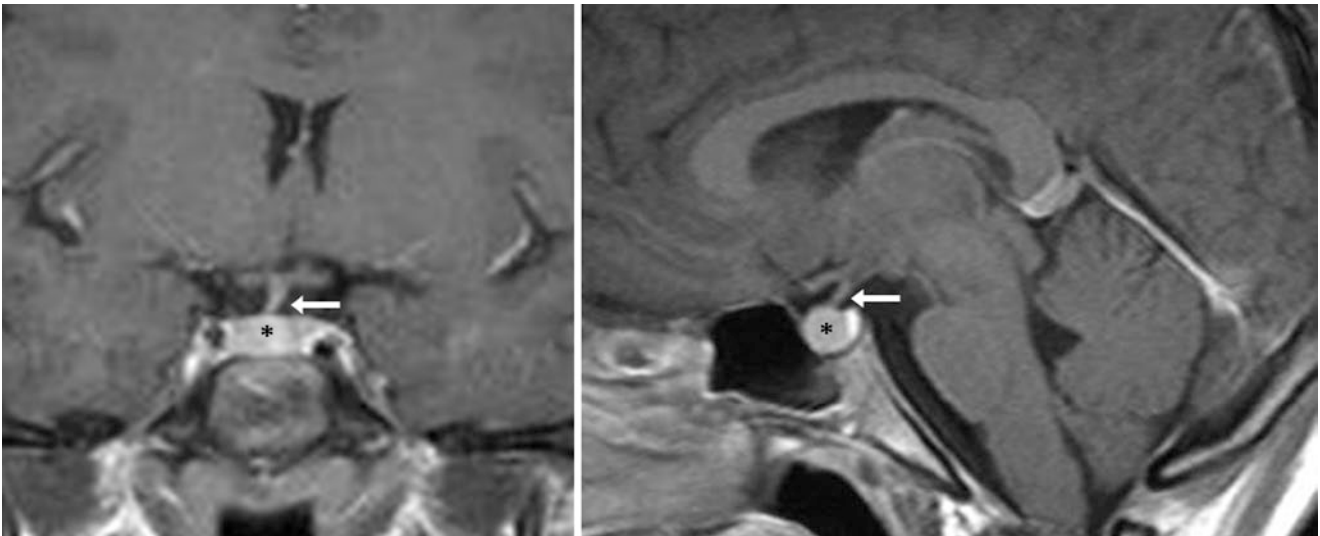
The patient was a 12-year-old female with headaches (thought related to migraines), with a 1.5 T MRI that demonstrates normal mild infundibular shift to the right (*arrow*) on postcontrast coronal
